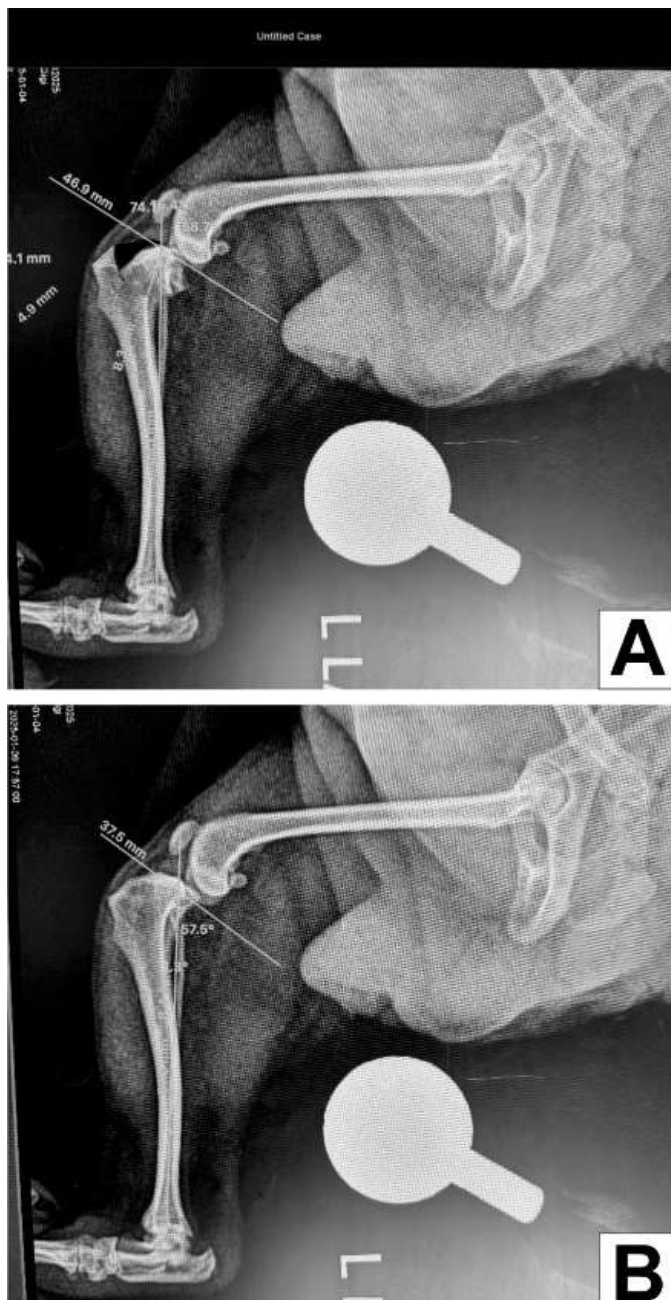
Virtual surgical planning. using VPOP software, surgeons can virtually measure, plan the osteotomy, and select implants on pre-operative radiographs, streamlining the surgical process and enabling faster, safer, and more accurate execution during the actual procedure.
